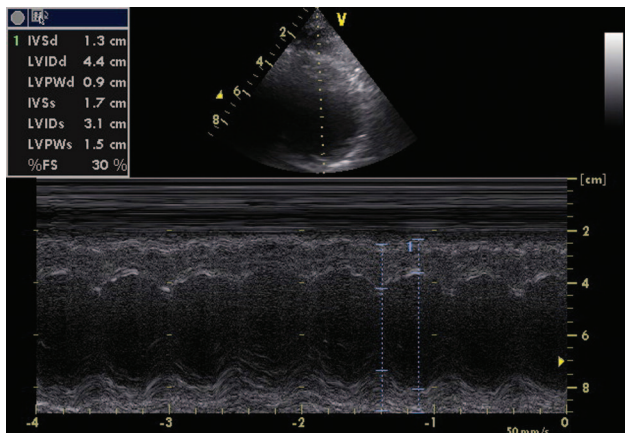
Two-dimensional and M-mode echocardiographic parasternal short-axis view of the left ventricle showing a normally sized left ventricle with good systolic function, and a slight left ventricular wall thickening
